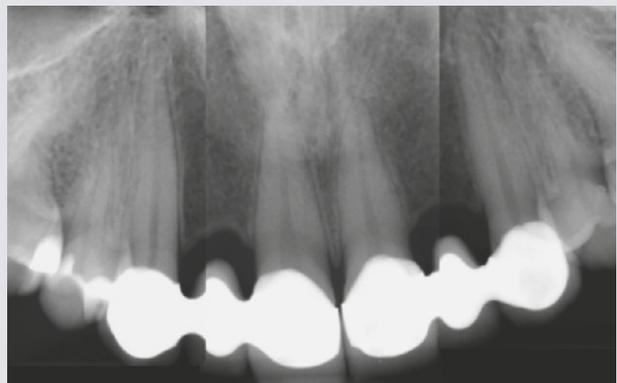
Detailed radiograph. Due to the large root canals (shown here), a minimalist new preparation is essential to avoid devitalization of the abutment teeth.
